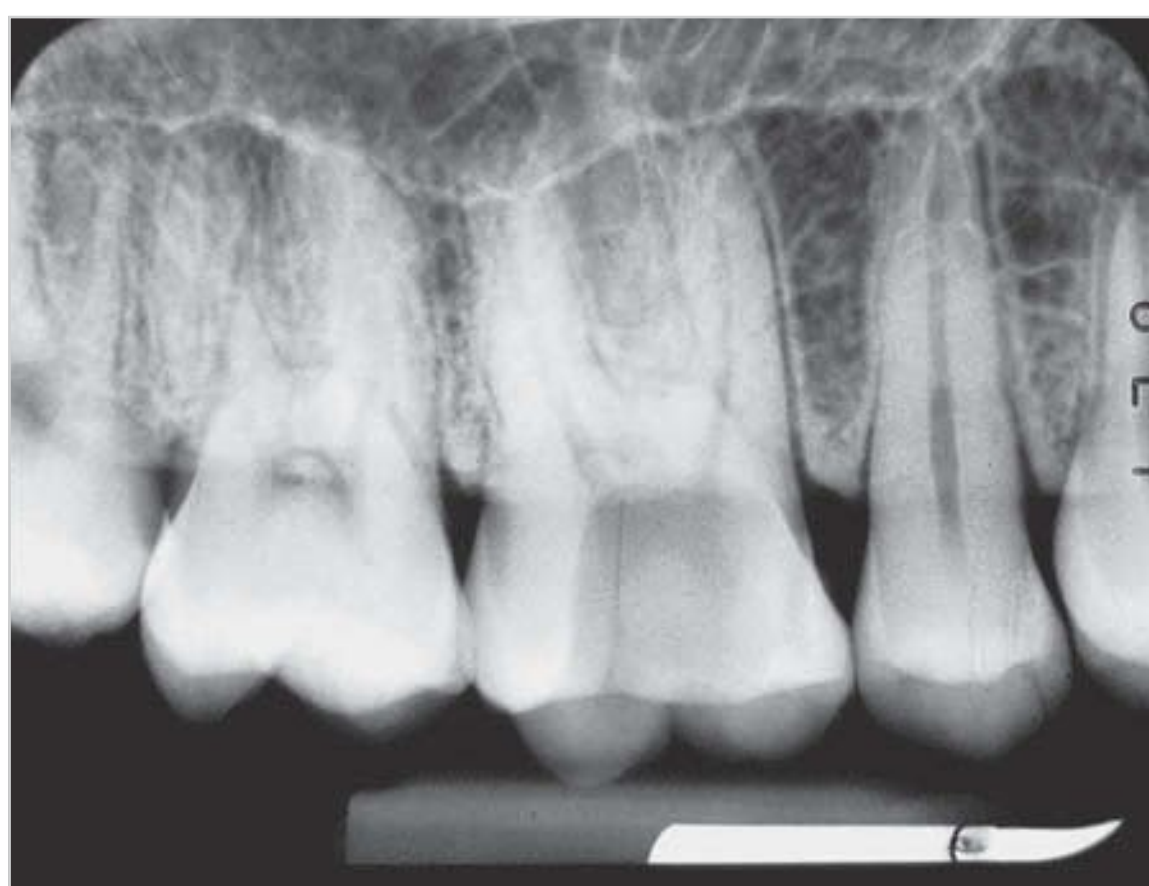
The comparison radiograph obtained with the paralleling technique has no distortion.
